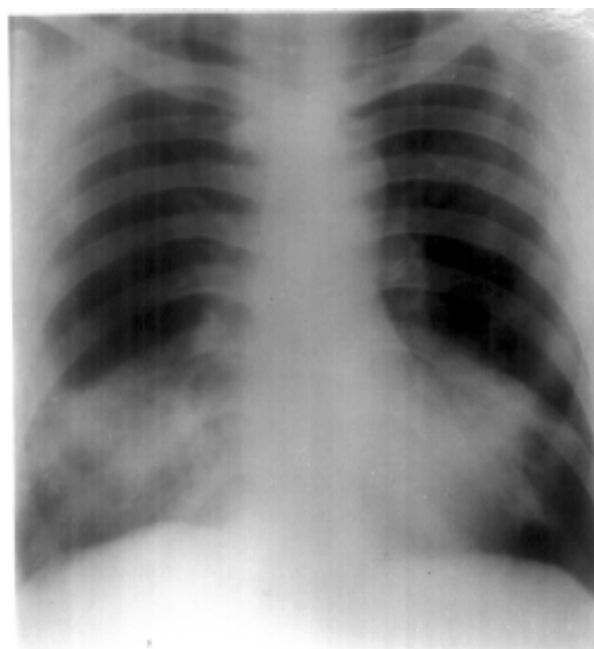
Chest roentgenogram (PA view) showing bilateral, non-segmental, homogeneous opacities in the lower zones.
